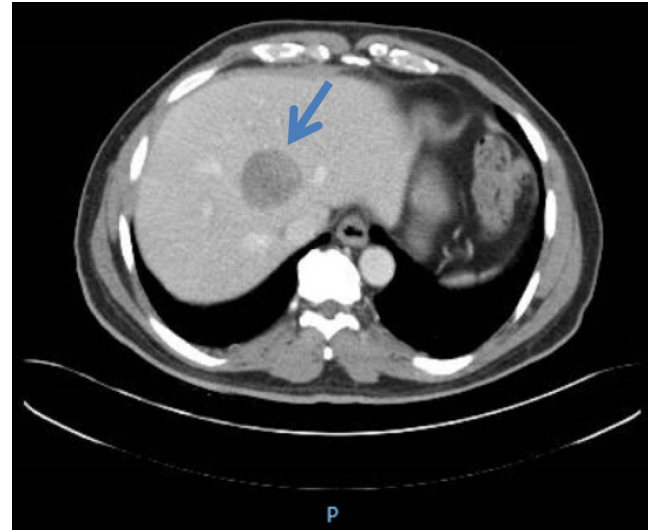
CT abdomen showed a solitary solid heterogeneous liver mass in the segment 4 of liver measuring 3.5 cm × 3.5 cm.
